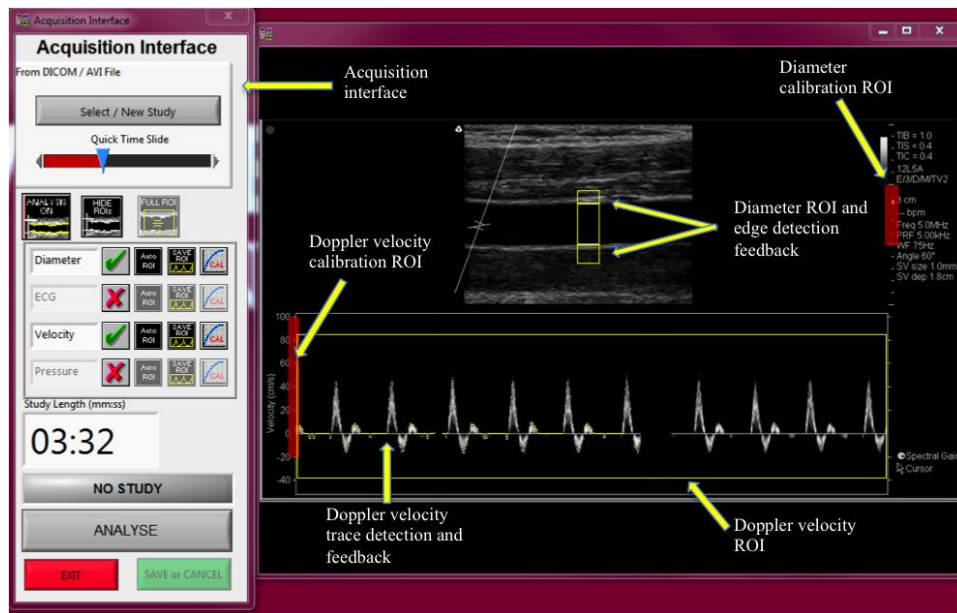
Example of the edge tracking software which provides beat-to-beat measurements of changes in SFA diameter and blood velocity displaying calibration ROI of the vessel and Doppler trace, diameter ROI, and the Doppler velocity ROI
